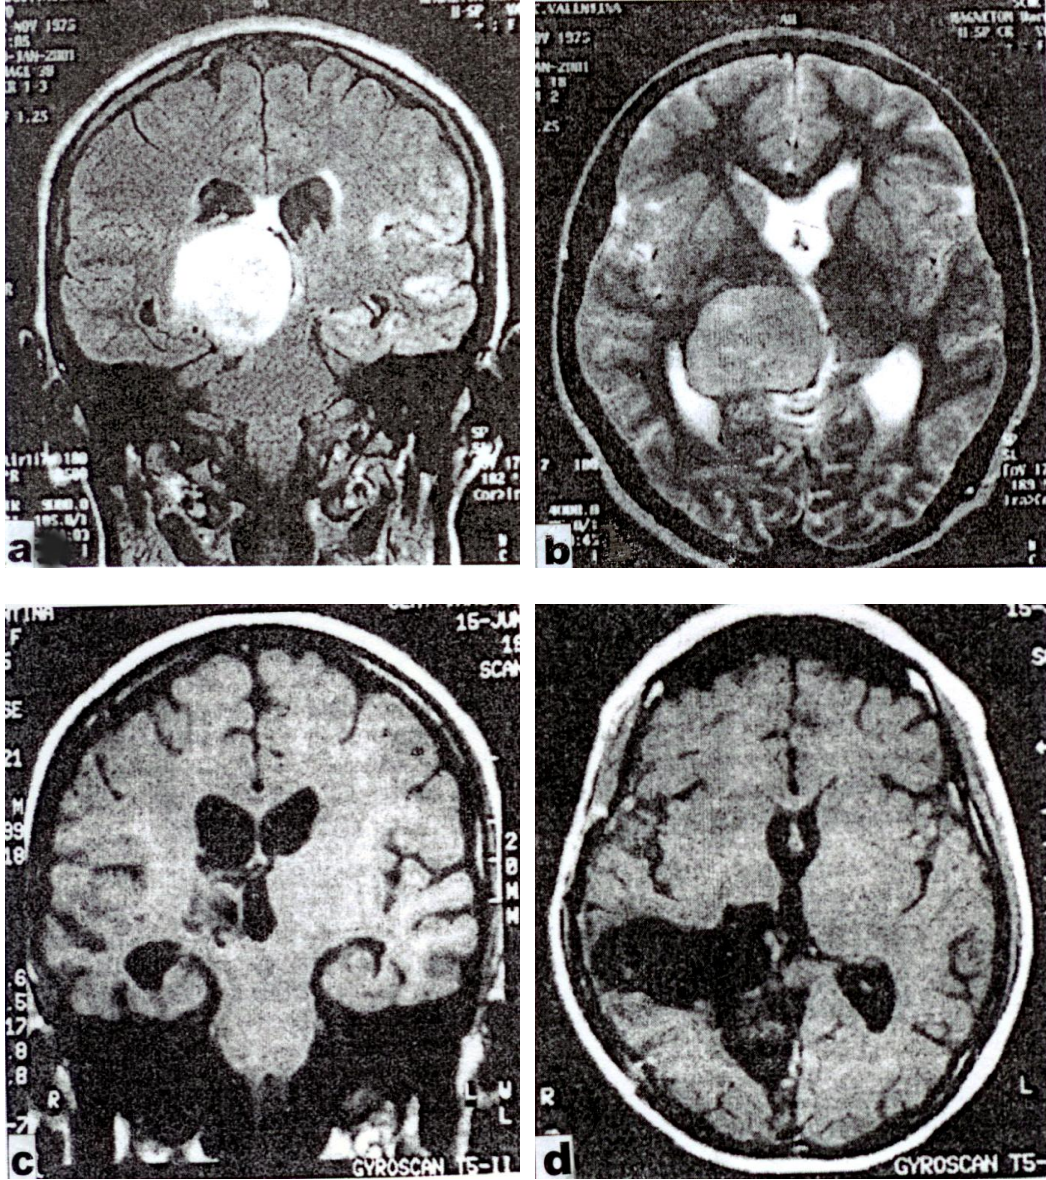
Contrast medium-enhanced coronal (a) and axial (b) magnetic resonance imaging showing a big right thalamic tumor that proved to be an astrocytoma. Thirteen months following resection and radiotherapy coronal (c) and axial (d) magnetic resonance imaging demonstrates the absence of tumor. The patient was consciousness and in good state.
